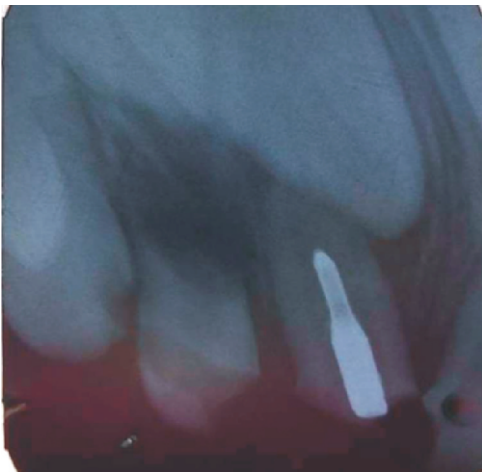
Preoperative radiograph showing radiopacity in the root canal of 61 likely a foreign body.
